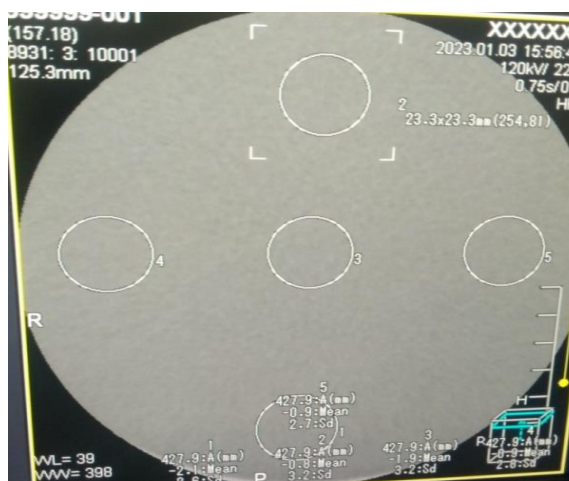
Scanner II CT QC image for;
